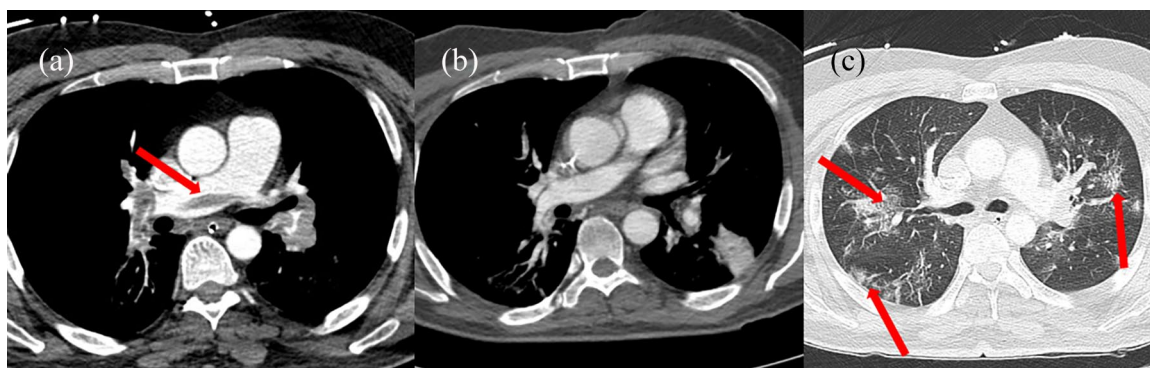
(a,b) Coronal computed tomography angiography (CTA) showing saddle pulmonary emboli with interlobar extension (arrow). (c) CTA showing ground glass opacities (arrows).
